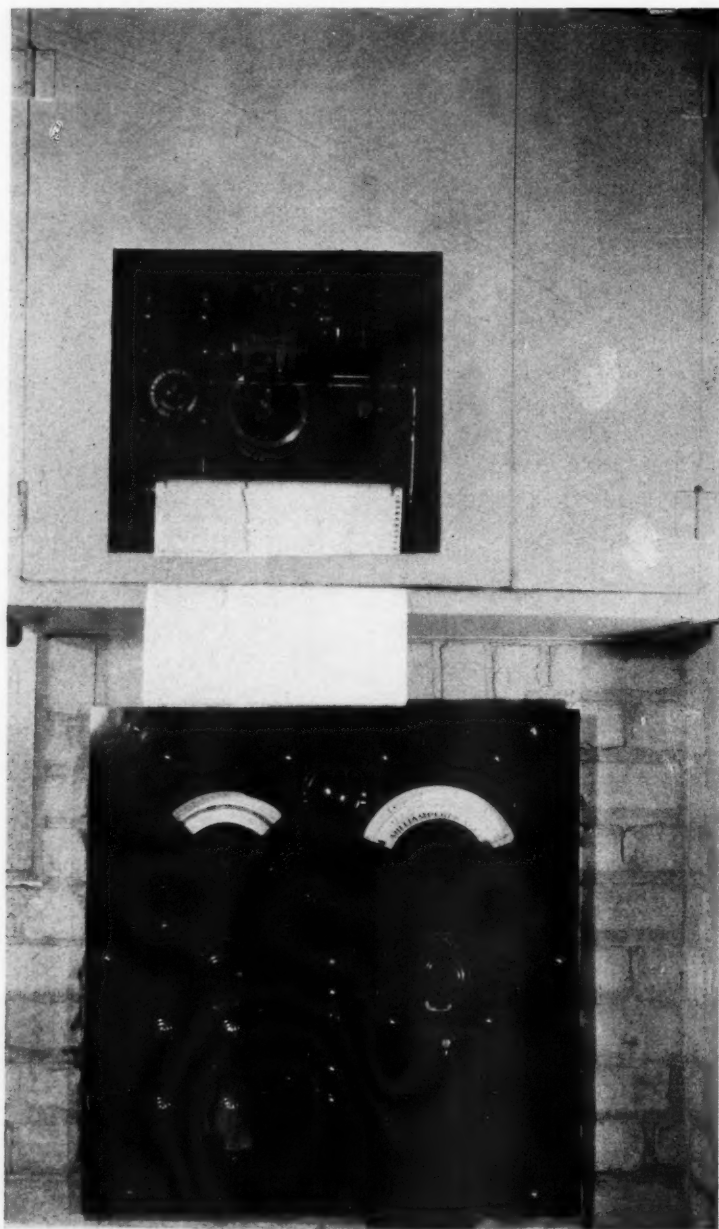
Panel board of X-ray control and recording meter.
